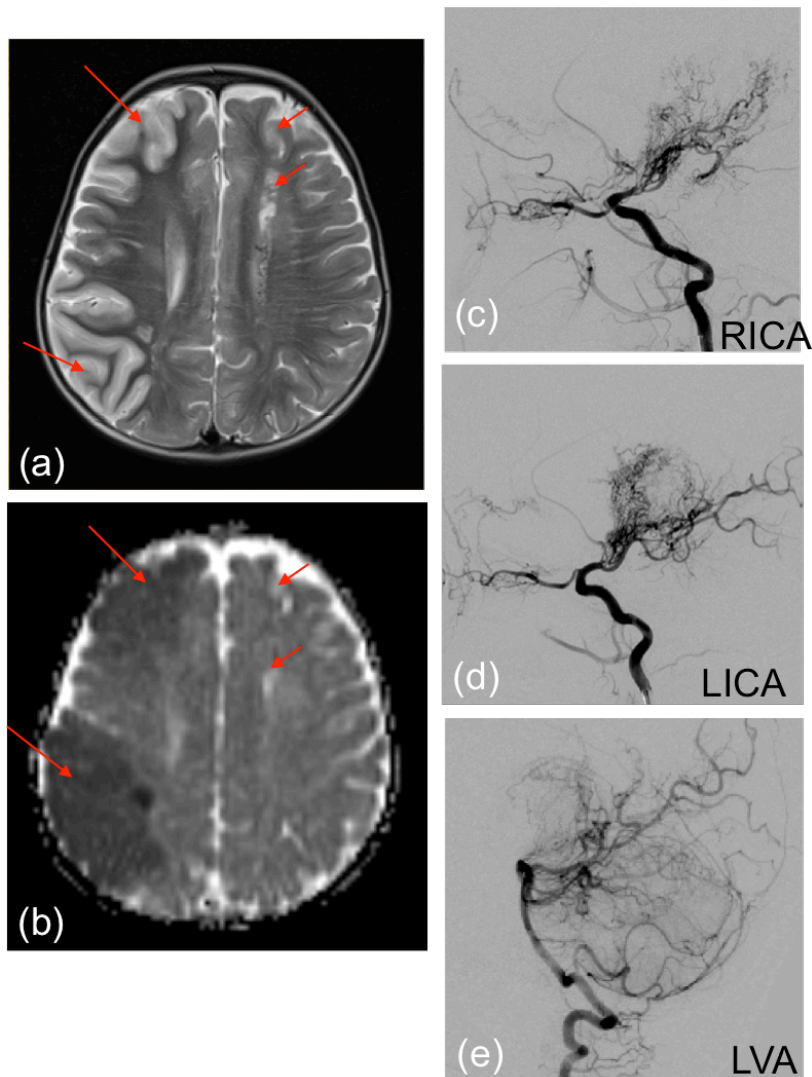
Brain magnetic resonance imaging (MRI) and cerebral catheter angiography images for B-II-3.
